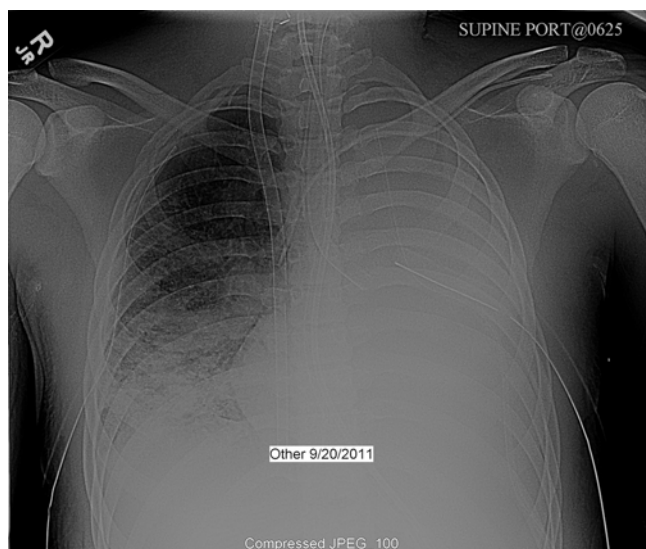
Chest radiograph of patient supported with venovenous ECMO demonstrating multilumen cannula inserted through right internal jugular vein into right atrium
